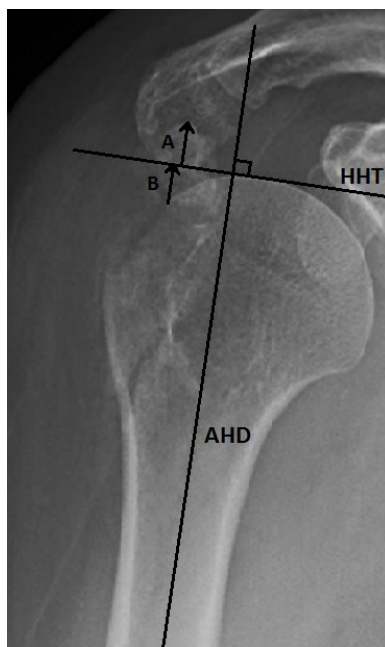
Measurement of the GT Ratio on Plain Radiography for Superior/Inferior Displacement
